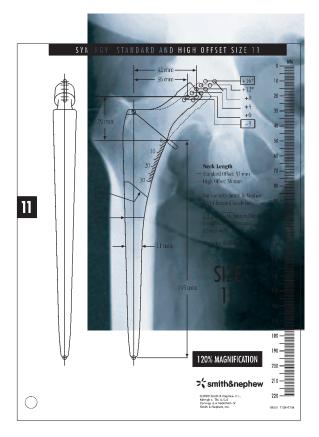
Anteroposterior radiograph demonstrating proper templating of a femur
